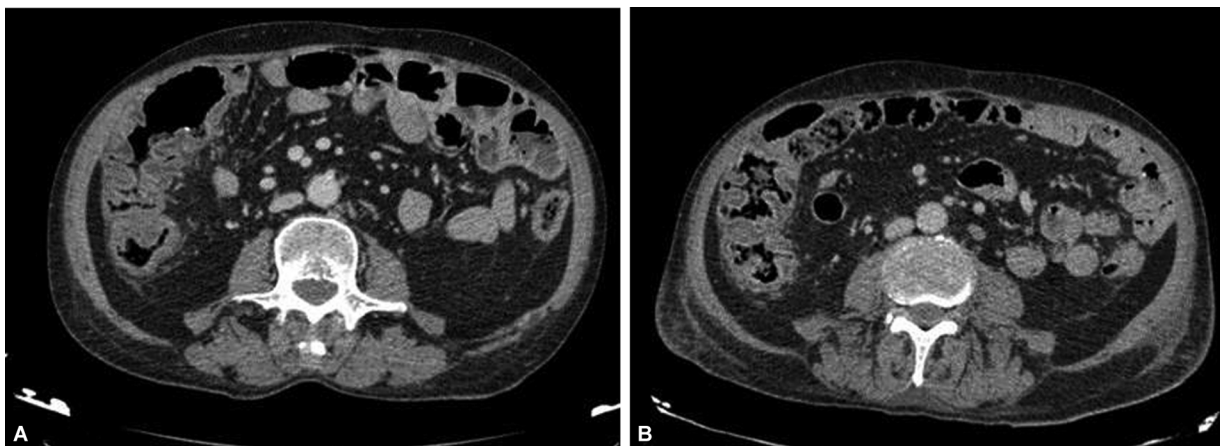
(A) Computed tomography (CT) of the abdomen with intravenous contrast revealing marked concentric parietal thickening of the cecum and ascending colon. (B) Increased extent of concentric parietal thickening of the ascendant and cecum on subsequent abdominal CT scan with intravenous contrast.
